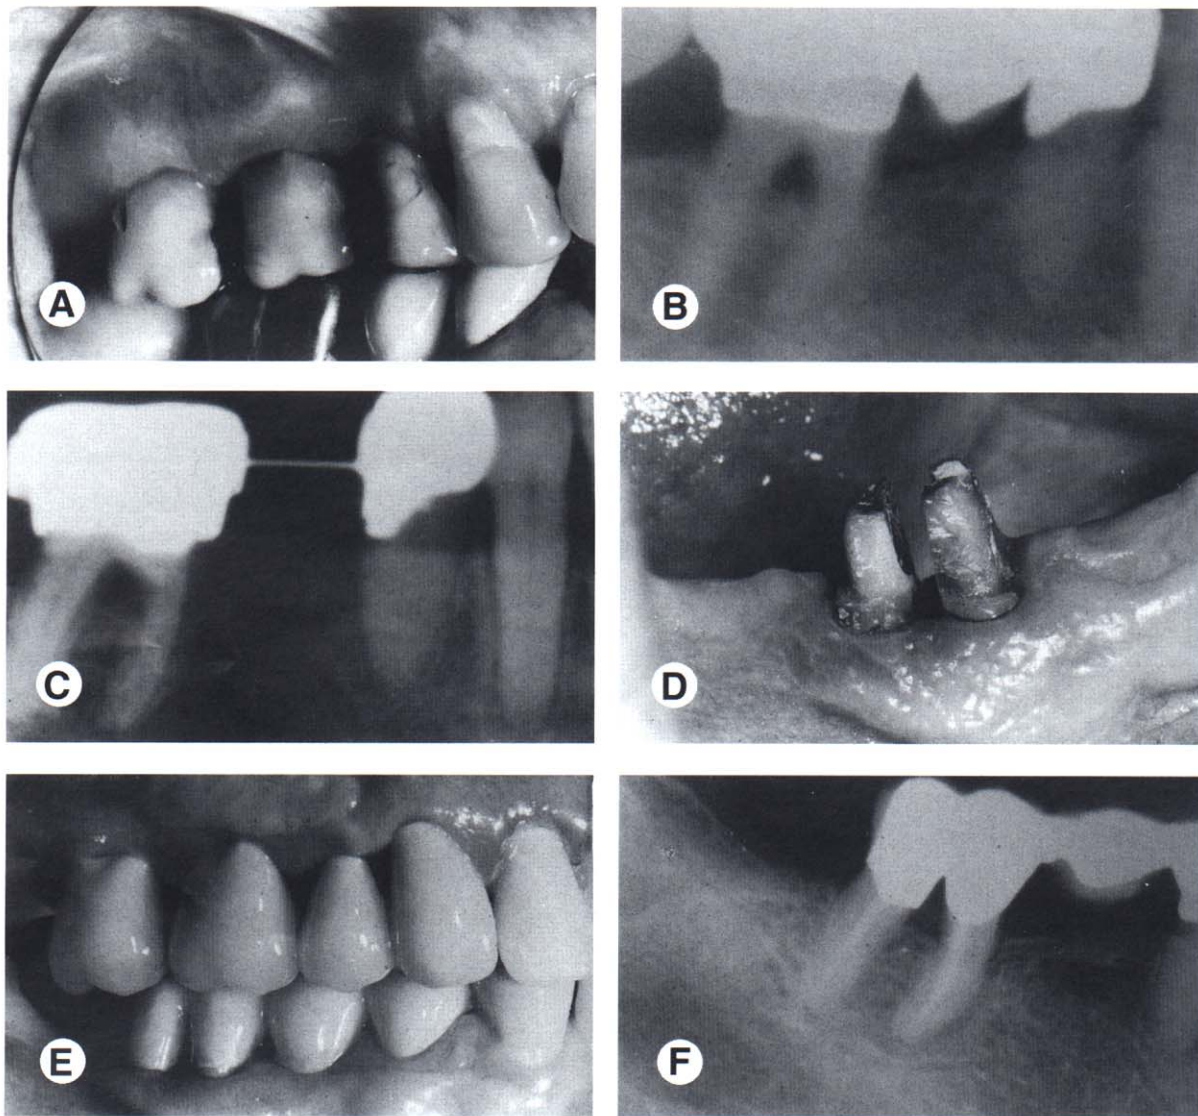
This patient had a Class III furcation defect before orthodontic treatment (A and B). Orthodontic treatment was performed and the furcation defect was maintained by the periodontist on 2 month recalls until after orthodontic treatment (C). After appliance removal, the tooth was hemisected (D) and the roots were restored, and splinted together (E). The final periapical radiograph (F) shows that the furcation defect has been eliminated by hemisecting and restoring the two root fragments.
